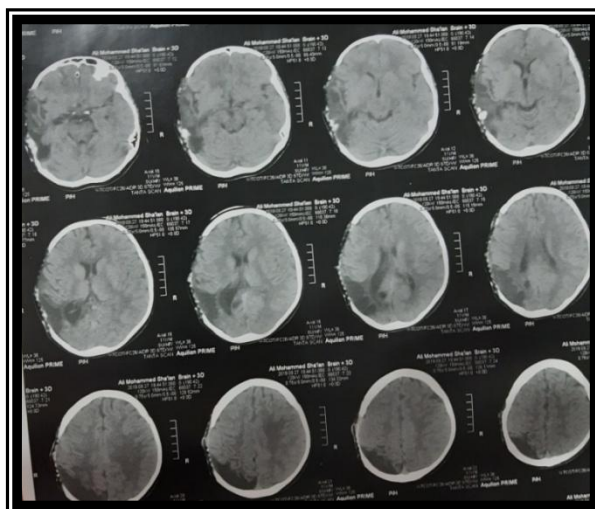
Post-operative axial CT brain showing the closure of the defect with medpore
